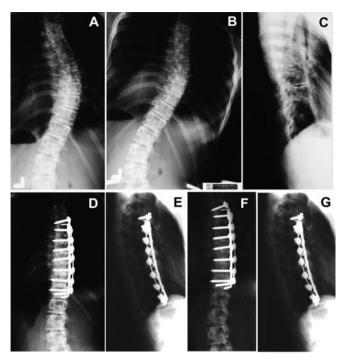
A 14-year-old girl with a right thoracic curve. The measurements on posteroanterior and laterolateral radiographs of the erect spine were carried out before surgery, 30 days after the surgery and at least 2 years after the surgery. A. Preoperative posteroanterior radiograph (Cobb angle of 56°). B. Right side bending radiograph evaluate flexibility of thoracic curve (Cobb angle of 36°). C. The lateral view demonstrates hypokyphosis (Cobb angle of 12°). D. First postoperative erect posteroanterior radiograph (30-day after surgery) showed excellent correction in frontal plane (Cobb angle of 4°). E. On first postoperative lateral radiograph balance in sagittal plane was restore (Cobb angle 22°). F. Posteroanterior radiograph obtained 2 years after surgery, showed minimal lost of correction for 2° (Cobb angle of 6°). G. Lateral radiograph obtained 2 years after surgery, showed no difference in sagittal plane (Cobb angle of 22°).
